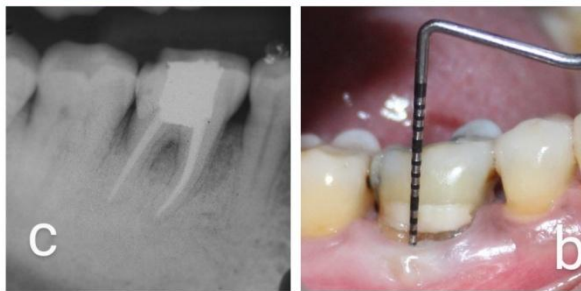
18 months postoperative buccal and radiographic view
